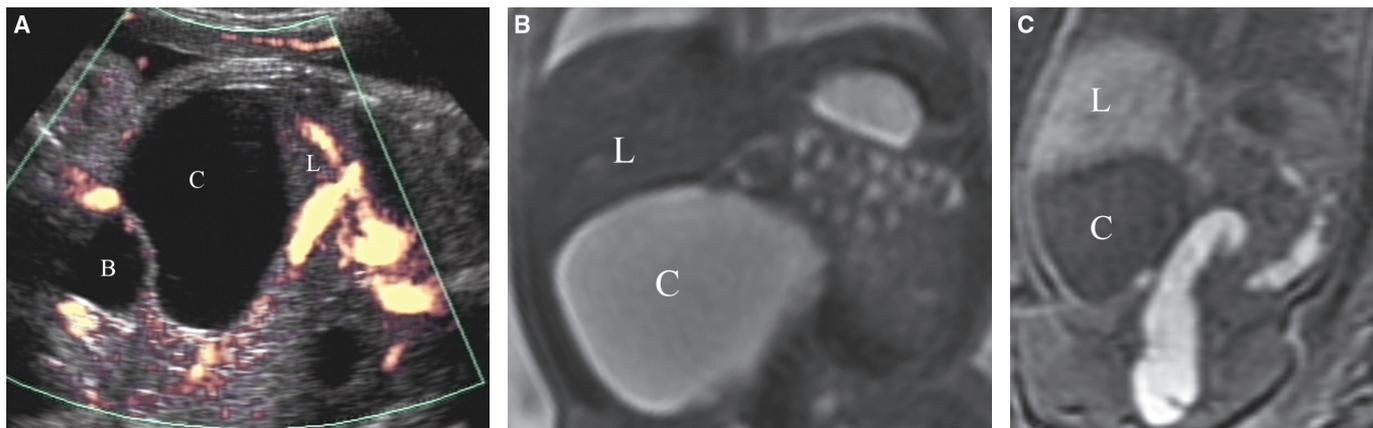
Hepatic cyst at 27 weeks' gestation. A: Coronal color Doppler US demonstrates a large anechoic cyst (C) along the inferior margin of the right lobe of the liver (L), separate from the bladder (B). There is no internal Doppler flow. B: Coronal MR image demonstrates hyperintense T2 fluid signal in the cyst (C) at the inferior margin of the right hepatic lobe (L). C: Coronal T1w MR demonstrates hypointense fluid signal of the cyst (C) at the inferior margin of the right hepatic lobe (L).
